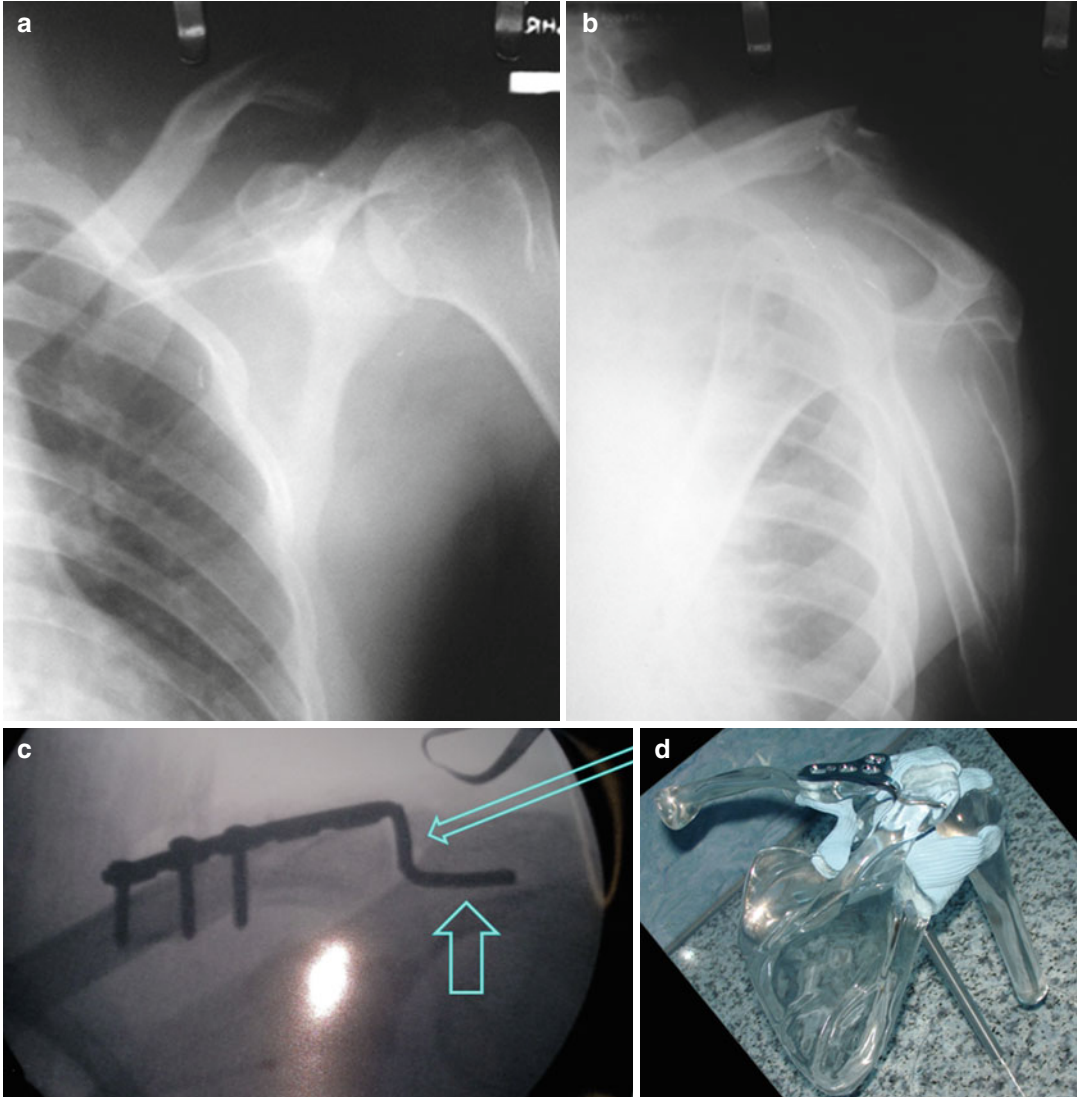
(a) Grashey and (b) scapula Y radiographs showing a displaced and comminuted distal clavicle fracture. The surgeon opted to perform ORIF with a hook plate. (c) This hook plate can be fashioned in the hospital workshop out of a 3.5 mm recon plate preoperatively and sterilized for surgery (courtesy of Dr. Tul Bdr Pun, Tansen
